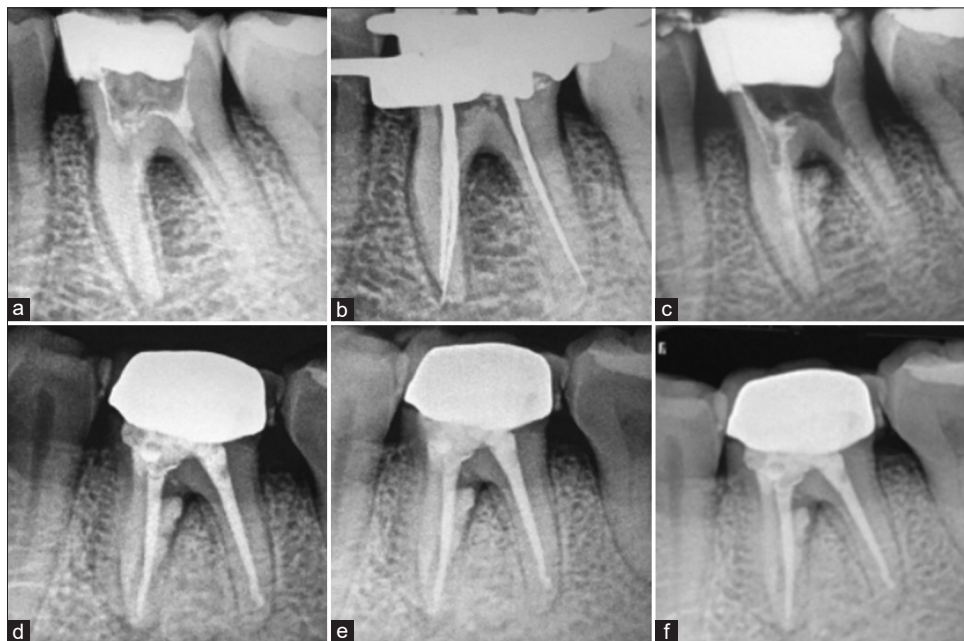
Radiographs. (a) Preoperative IOPA depicting stripped canal (b) Stripped canal is confirmed with working length IOPA (c) MTA packed in stripped mesiolingual canal. (d) 3 months postoperative IOPA. (e) 6 months postoperative IOPA. (f) Postoperative radiograph after 1 year
